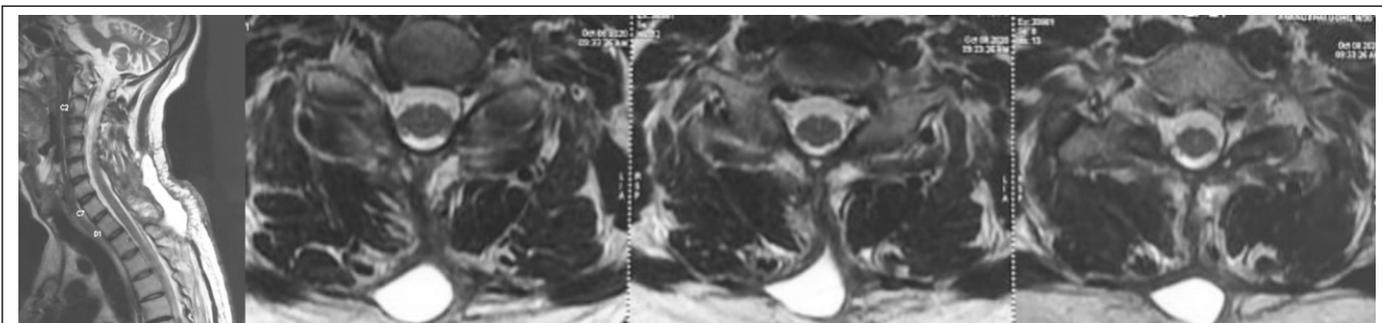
T2 sagittal and axial images of MRI of cervico-dorsal spine at 3-month postoperatively showed resolution of epidural hematoma with adequate decompression of spinal cord except small collection found in posterior myofascial plane.
